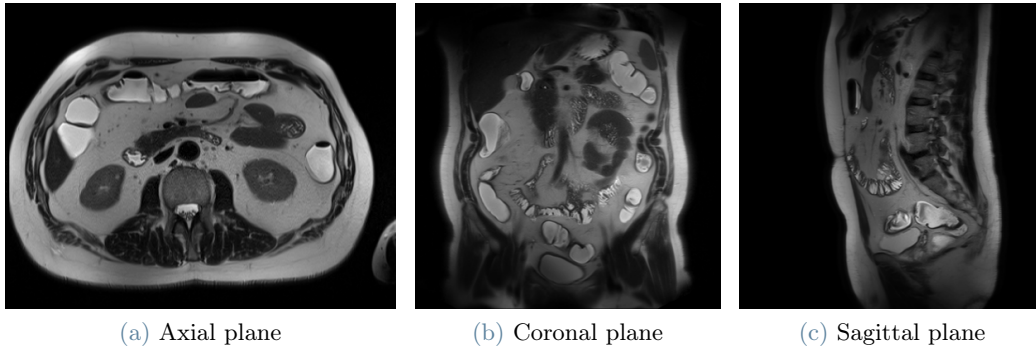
Example of axial, coronal, and sagittal center slices from T2-weighted MRE HASTE images
